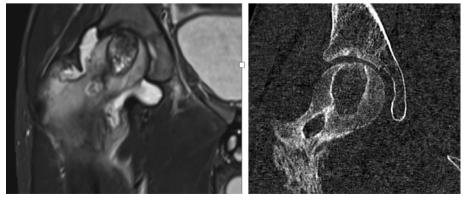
A, B: a MR-scan (A) and CT-scan (B) scan 4 months after operation show local recurrence of chondroblastoma with progressive destruction of the femoral head.
